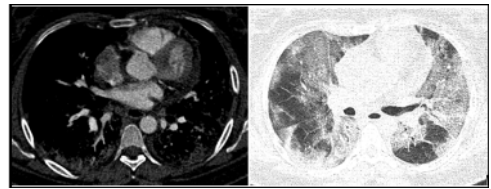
Axial CTPA image showing inclusion defect/thrombus in the lateral basal segment branch of right pulmonary artery and axial HRCT image showing moderate to severe lung involvement evident by large areas of ground glass attenuation and interstitial thickening.
